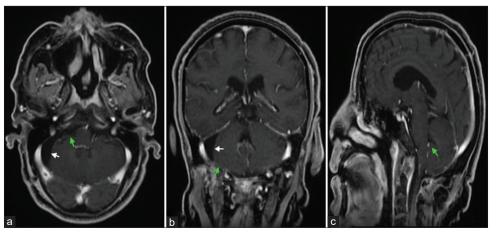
Are postoperative MRI showing total resection of the lesion at the right cerebellopontine angle (CPA). a = Axial, b = Coronal, c = Sagittal. Green arrow = no lesion. white arrow = CSF in the operative defect
